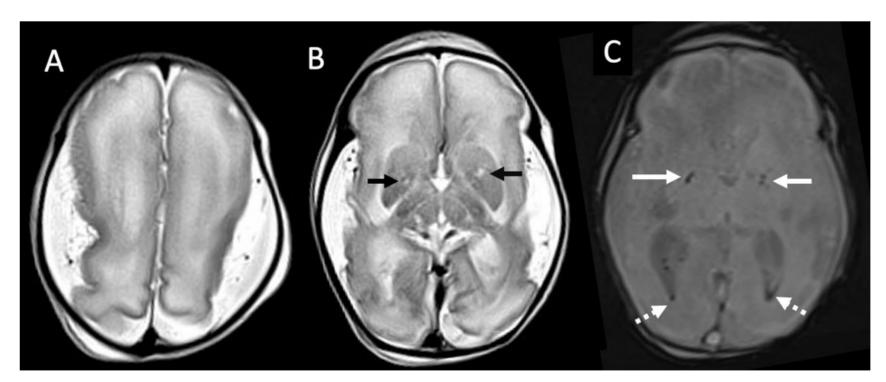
Patient with *TUFM* gene mutation. MRI was obtained at the age of 2 days. (A, B) Axial T2 weighted images show lissencephaly. Bilateral T2 hyperintensities are seen in the basal ganglia (arrows in B). (C) A susceptibility-weighted image shows susceptibility effects in the basal ganglia (solid arrows) and mild intraventricular haemorrhage (dashed arrows).
